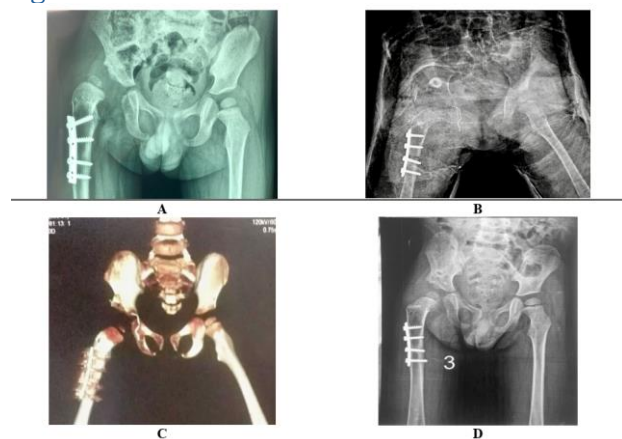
(A) Preoperative X-ray, (B) Immediate postoperative X ray shows pelvis in spica cast with good position of the graft, (C) Immediate postoperative CT shows good reduction of Rt hip with good position of graft in Dega osteotomy, (D) One year postoperative x ray
